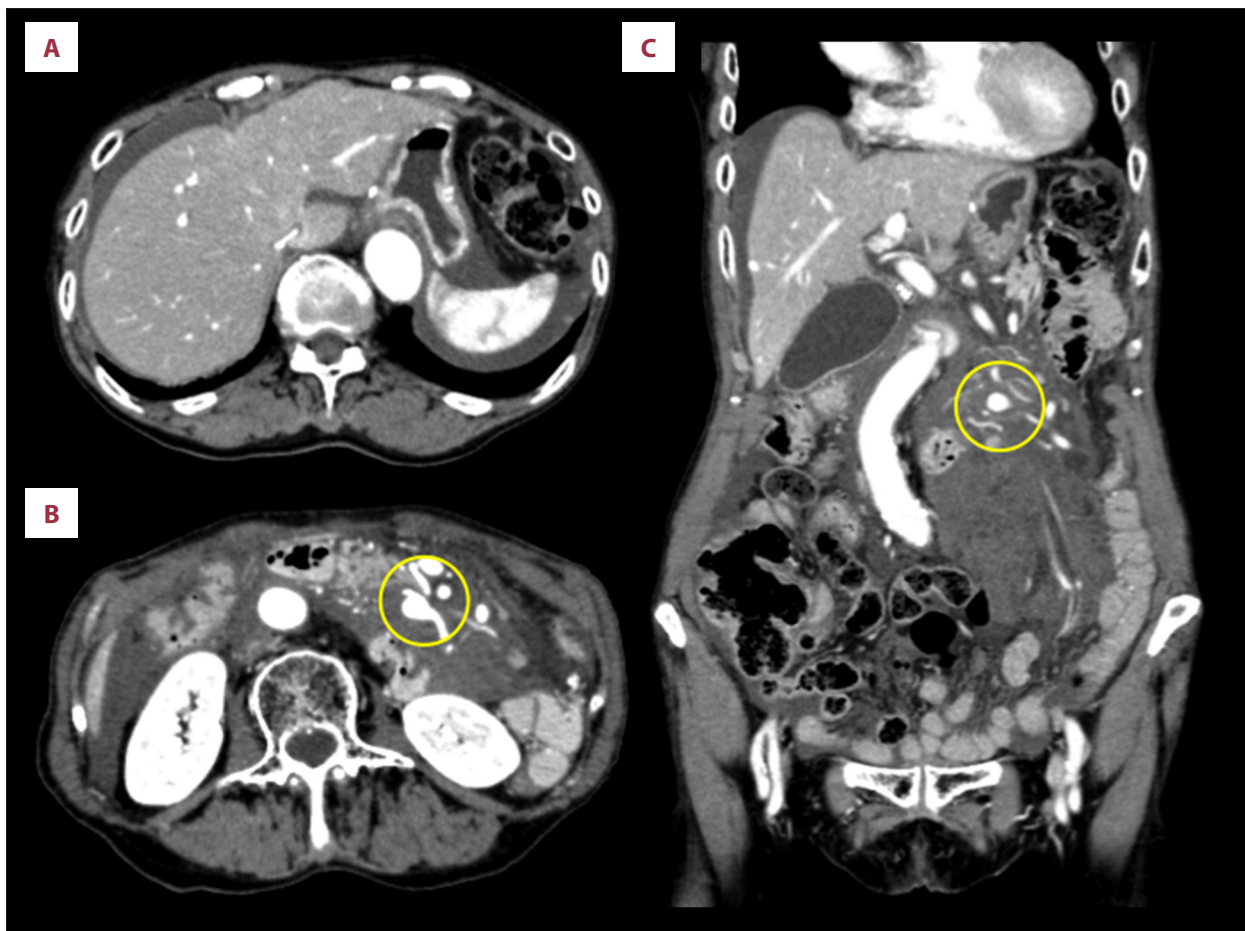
CT scan showing (A) fluid collection in the both the subphrenic and retroperitoneal spaces and (B, C) a pancreaticoduodenal artery aneurysm (yellow circle).
